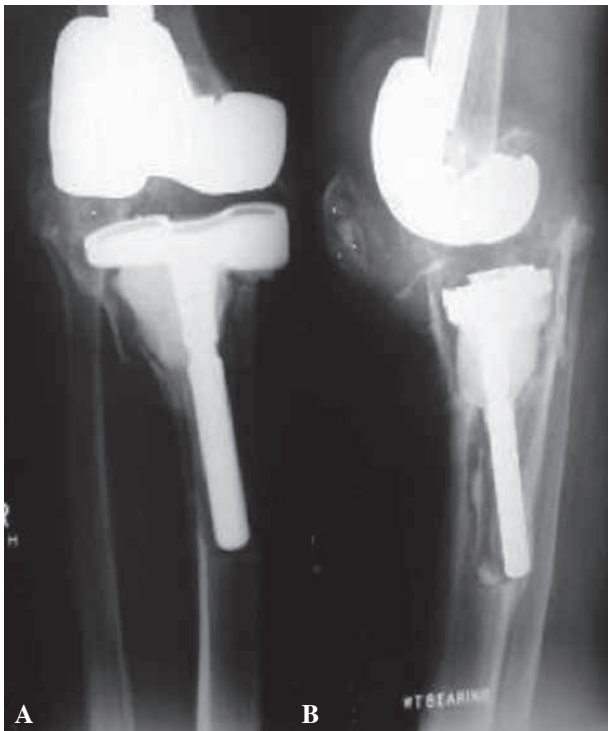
Preoperative anteroposterior (A) and lateral (B) radiographs of a right knee demonstrating an AORI type-3 tibial defect. (Permission granted to use these images from Nova Science Publishers, Inc).
